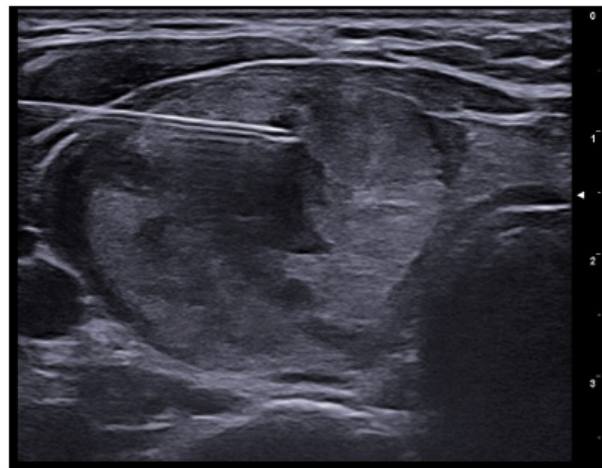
Ultrasound image showing a fine-needle inserted at the beginning of ethanol ablation treatment in a spongy-type nodule located in the right lobe of the thyroid gland.
